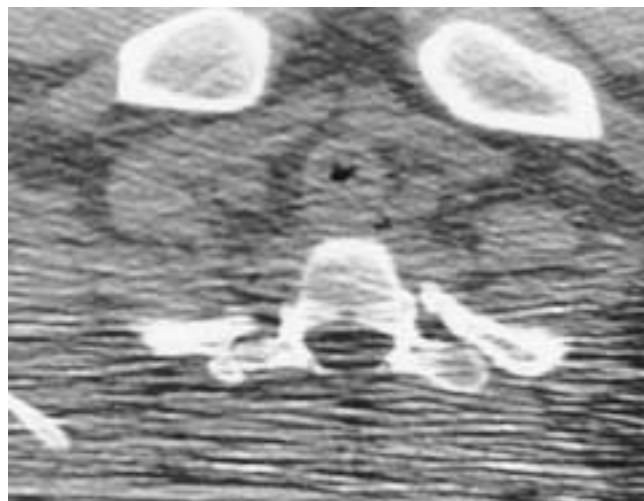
Circumferential granulation tissue causing tracheal stenosis in an 18-year-old boy with Down's syndrome and a history of long-term intubation following cardiac surgery. The patient now has intermittent respiratory distress. Spiral 1 mm thick axial CT scan shows circumferential endotracheal soft tissue causing marked airway compromise. The scan was performed during quiet respiration.
